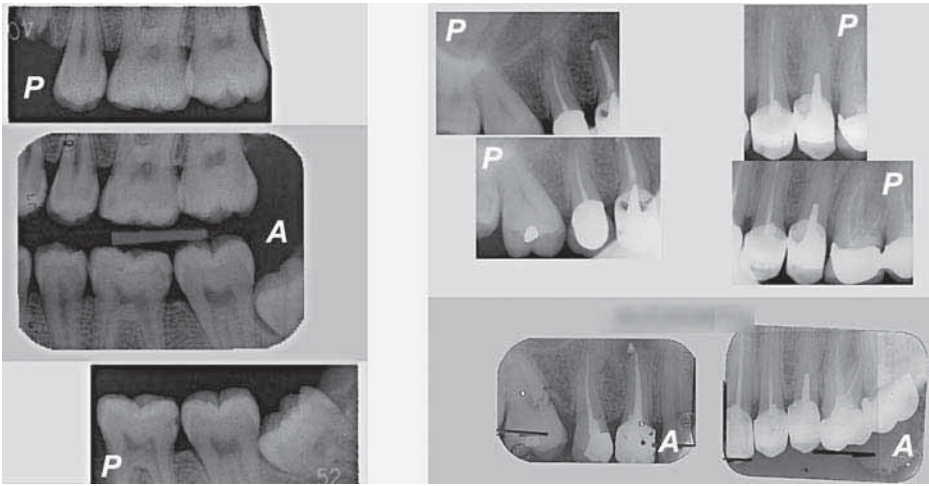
Identification by means of intraoral radiographs (A refers to antemortem images; P to postmortem ones). To the left, in the absence of therapy, the morphological characteristics of the single dental elements (crowns, roots, pulpar chambers) and their reciprocal positions (third left inferior partially included and mesioinclined); notice also the lesion from caries on the distal surface of the first inferior molar. To the right one can notice the similarities of root canal and dental restorations between A and P.
